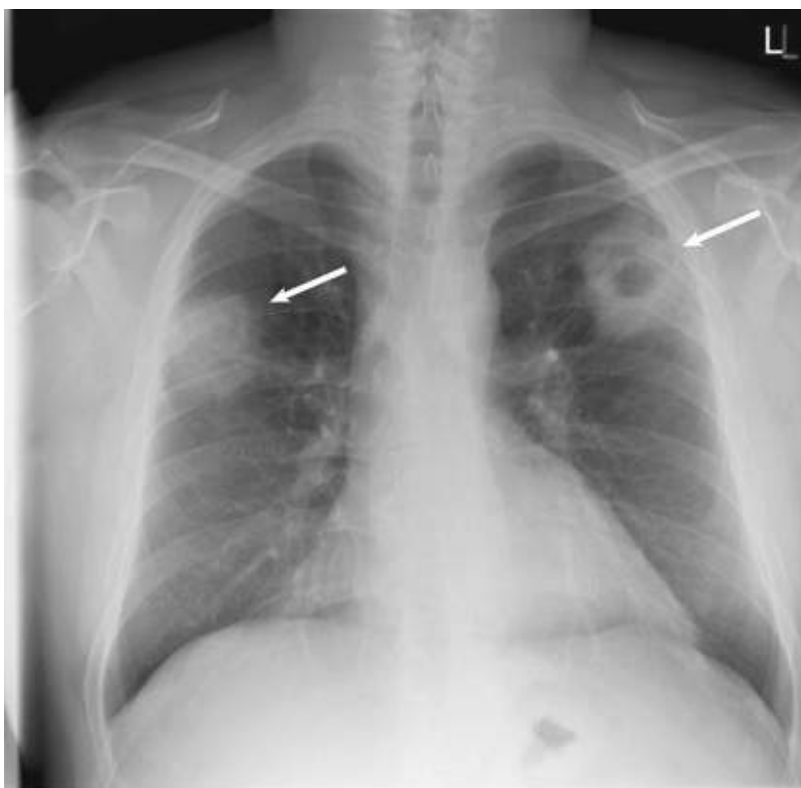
Granulomatosis with polyangiitis. Chest radiograph of a 36-year-old man showing pulmonary involvement with evidence of opacification and cavitation in the left upper lobe lesion (*arrows*).
